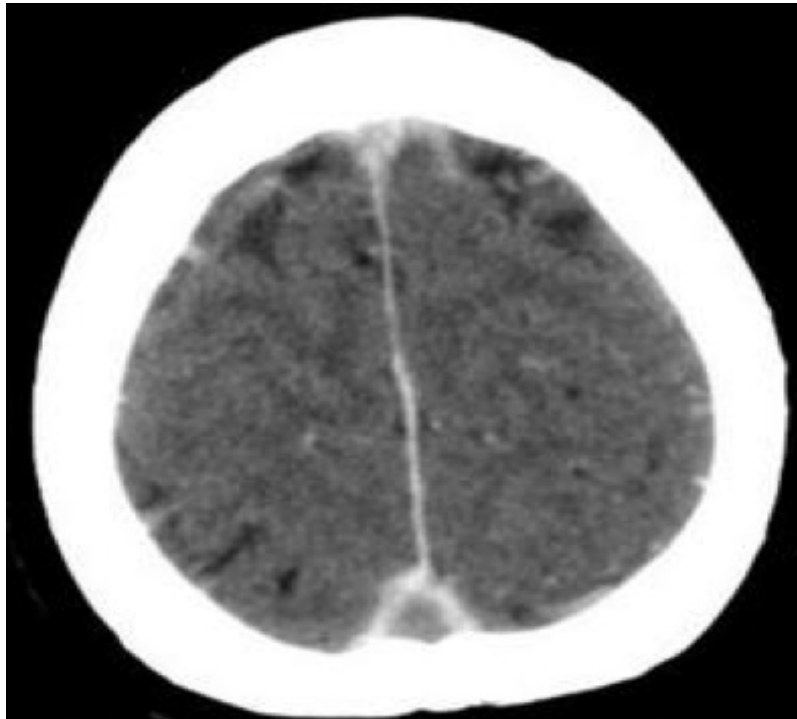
CT Brain demonstrating Empty delta sign
